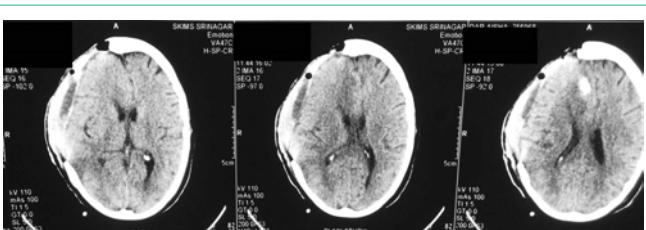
CT scan head showing only postoperative changes.
